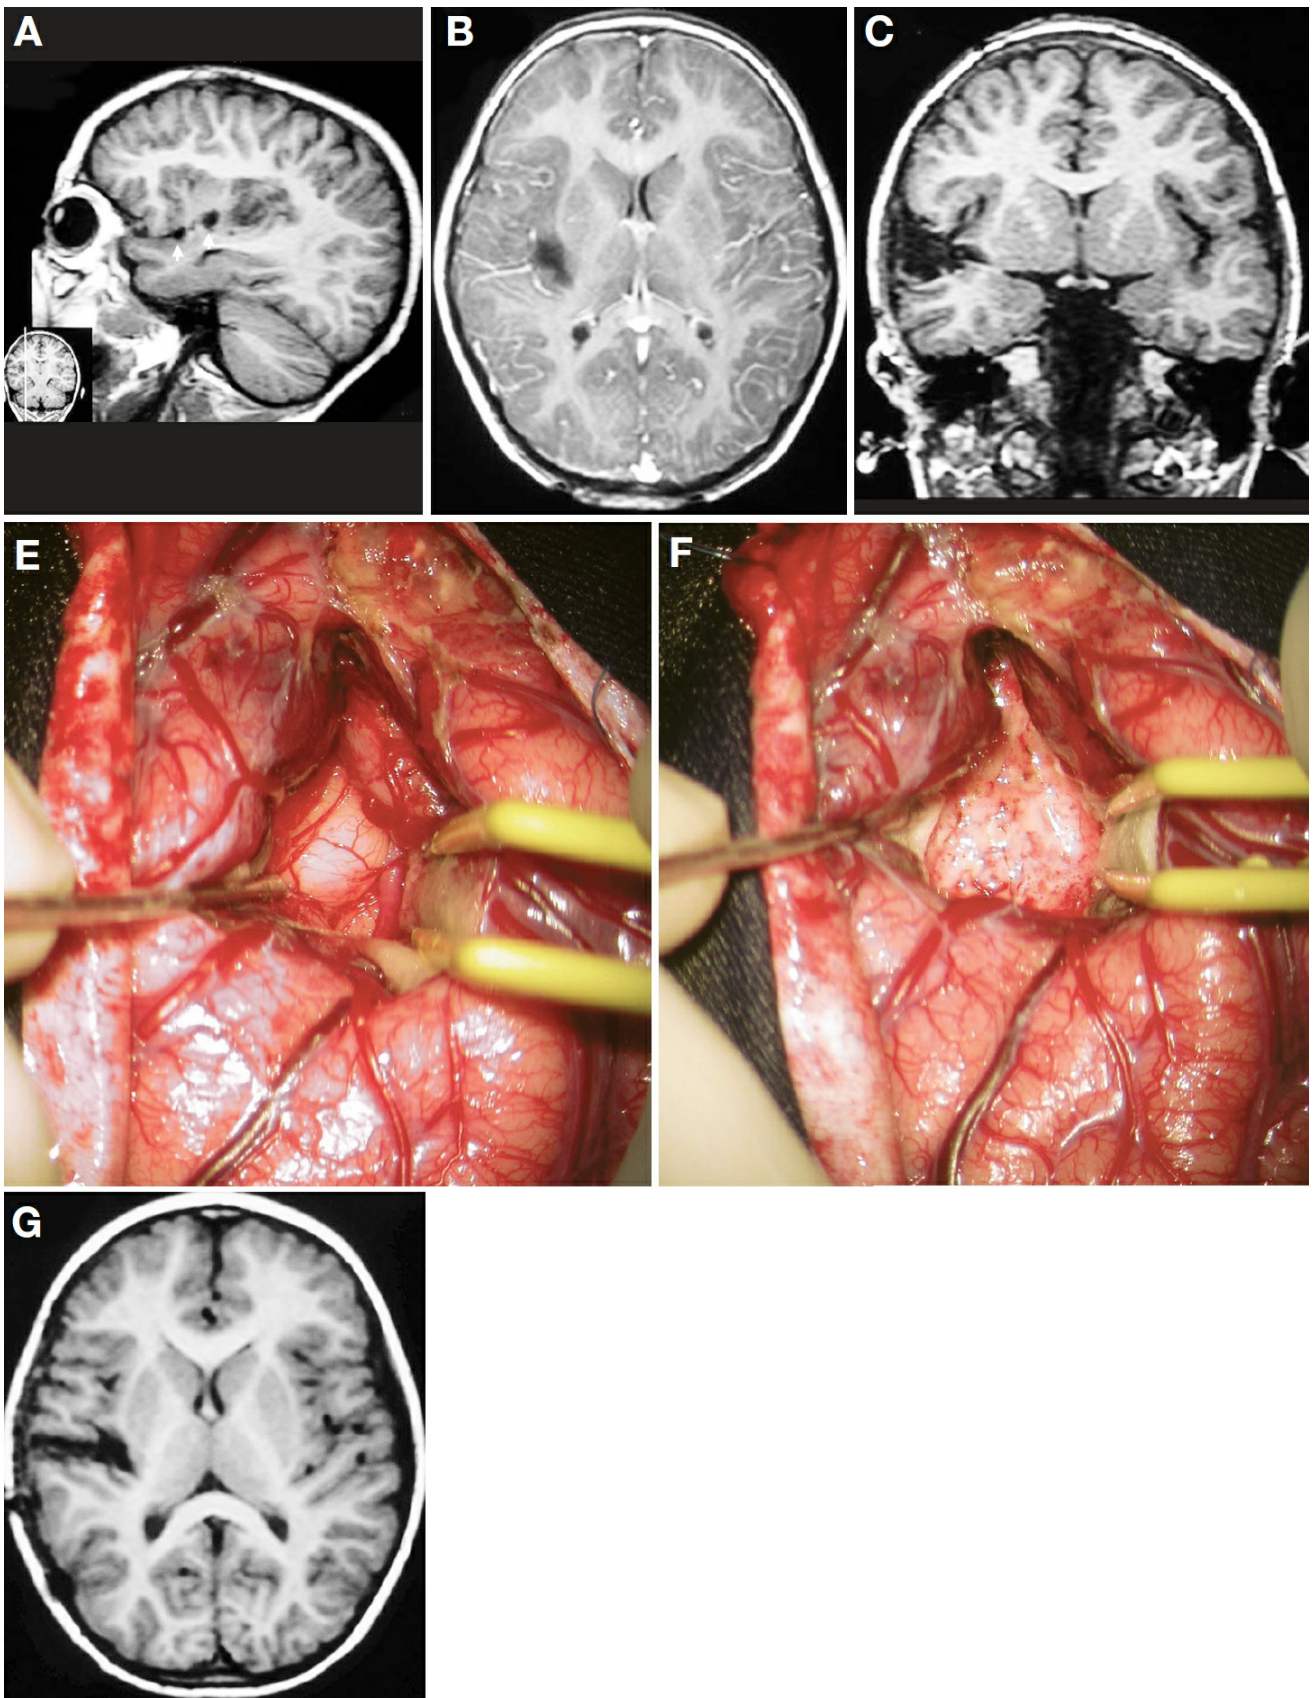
A, sagittal MRI scan. The tumor occupies the posterior zone of the right insula. The previous surgery apparently reached the anterior portion of the insula (arrows). B, axial MRI scan. The tumor occupies the posterior part of the insula. The posteromedial limit of the tumor is closely related to the posterior limb of the internal capsule; there is no intervening lentiform nucleus at this point. C, coronal MRI scan. The
